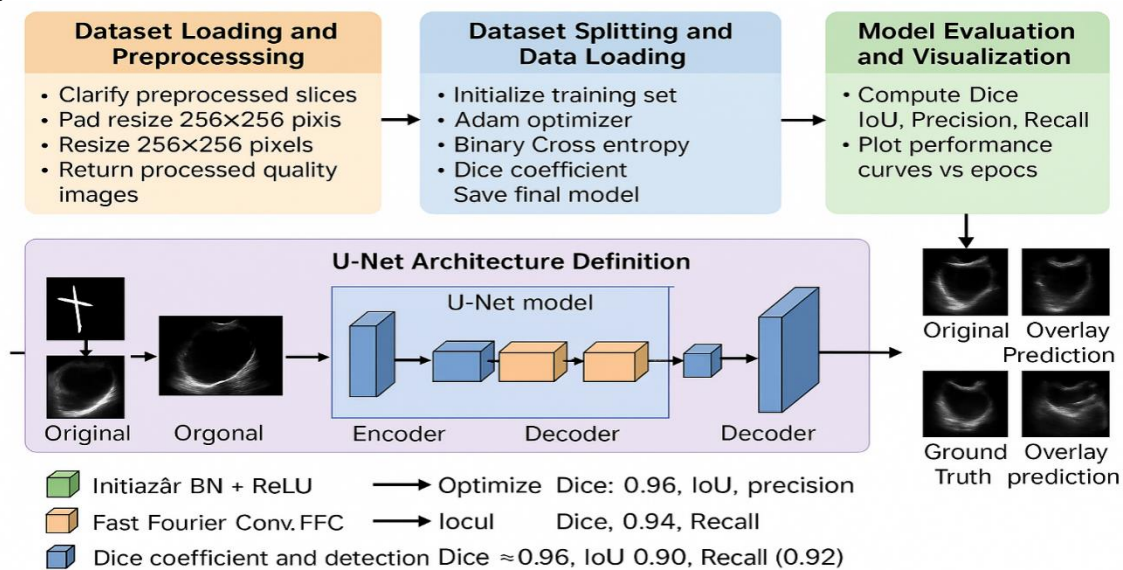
The complete workflow for ovarian ultrasound image segmentation
